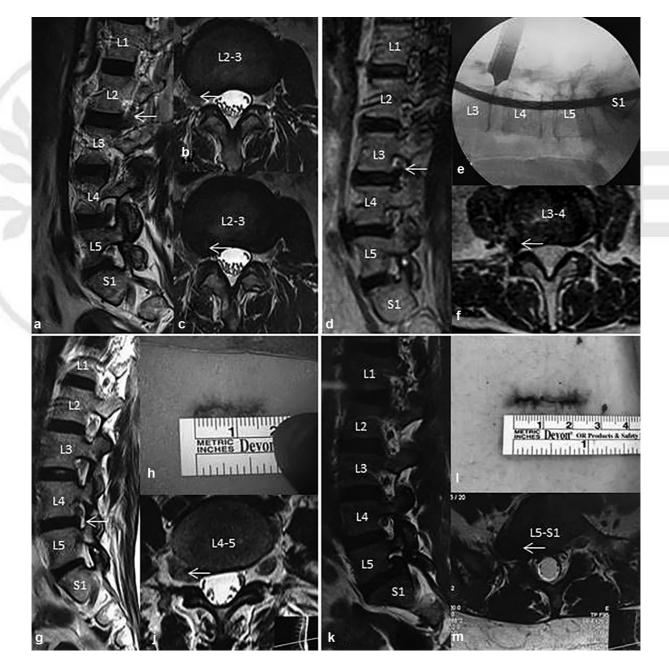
Preoperative T2-weighted magnetic resonance imaging (MRI) of L2–L3, L3–L4, L4–L5, L5–S1 far-lateral lumbar disk herniation (FLDH), sagittal images (*A*, *D*, *G*, *K*) and axial images (B, C, E, F, H, J, L, M).
